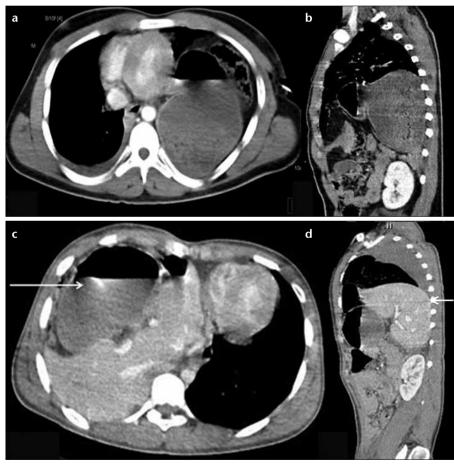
a–d. Axial (a) and sagittal (b) reformatted CT images show the stomach, omentum, and bowel loops lying in the intrathoracic region, causing a mild mediastinal shift to the right. The stomach is directly in contact with the posterior chest wall without the intervening diaphragmatic crus, suggestive of the dependent viscera sign on the left side. Axial (c) and sagittal (d) reformatted CT images of another patient display herniation of the liver and stomach (*long arrow*) into the right side of the thorax, with a mediastinal shift to the left. The posterior aspect of the liver is in direct contact with the posterior right chest wall, suggestive of the dependent viscera sign on the right (*short arrow*).
